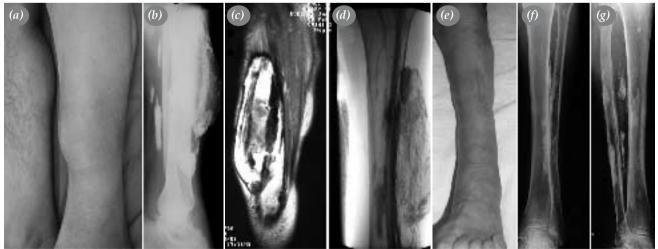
(a) Clinic and (b) radiographic view of soft tissue mass localized in the left leg of the patient. (c) a well-demarcated heterogeneous intensity rise including calcified foci in the magnetic resonance section (d) No vascular relation of the mass is seen in the peripheral angiographic examination. In 12th month of the postoperative period (e) clinical appearance and (f) antero-posterior and (g) lateral radiographs.
